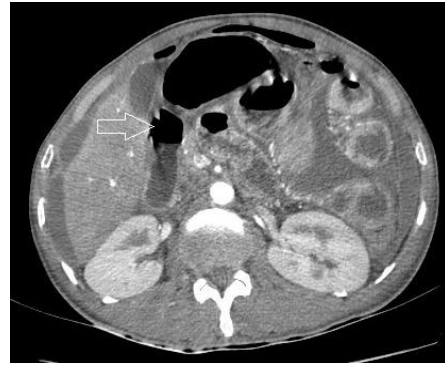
Axial CT abdomen arterial phase shows intraperitoneal free air, free fluid in peritoneal cavity, a rent is seen in the first part of the duodenum (arrow).
